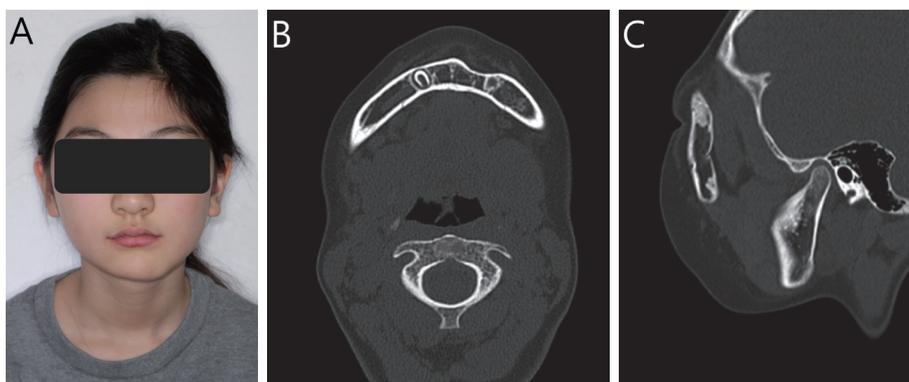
Clinical photo and 3D CT view after 4 years. (A) Facial asymmetry is seen in frontal photo. (B) The left parasymphyseal region is healed with irregular contour. (C) No specific findings on right condyle.
